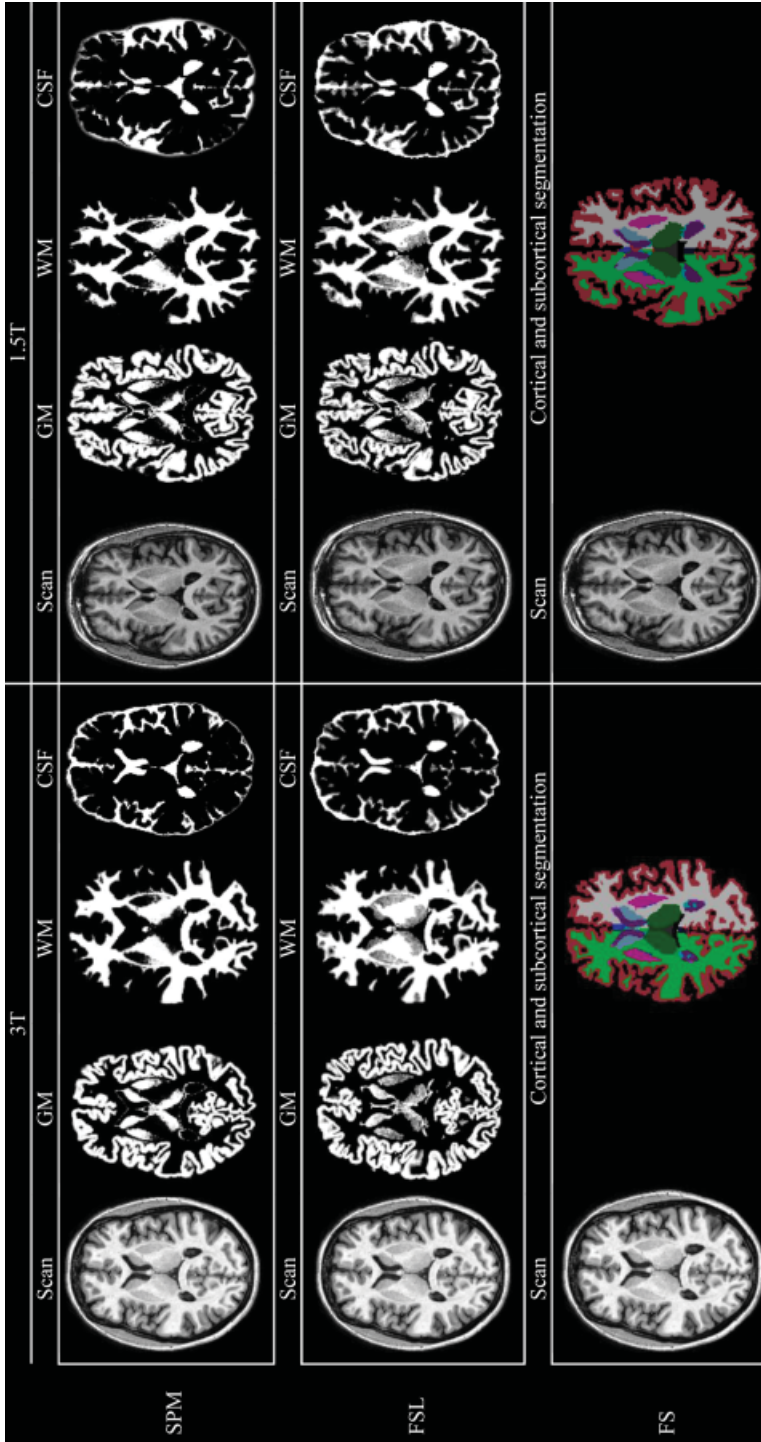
Automated brain volume measurements at 3T and 1.5T. Examples of the performed measurements for the robustness analysis for one subject on 3T and 1.5T MRI. Individual measurements are shown using a probabilistic (SPM and FSL) or a binary approach (Freesurfer). GM, gray matter; WM, white matter; CSF, cerebrospinal fluid.
